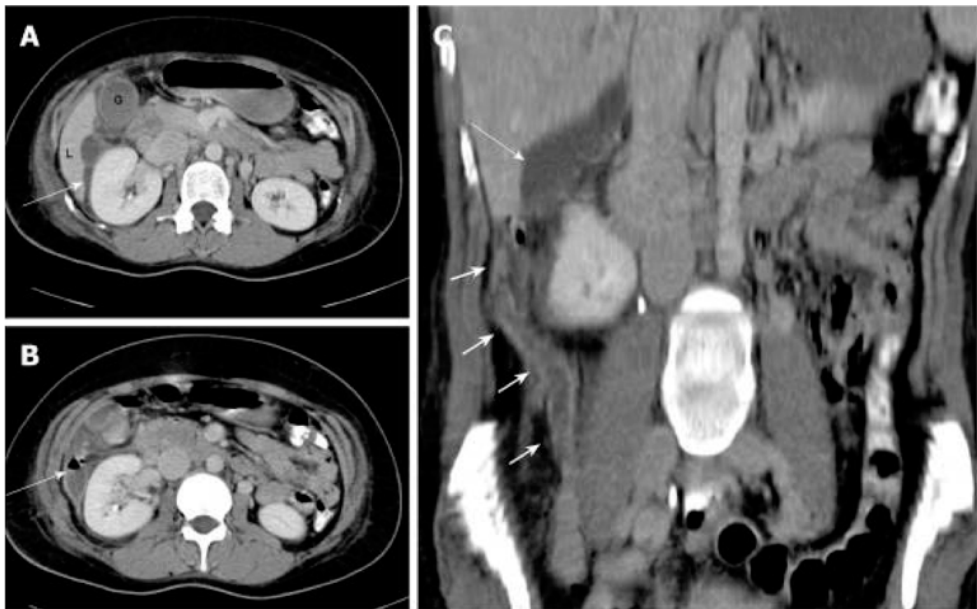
A – contrast-enhanced CT scan showing fluid collection (arrow) in the subhepatic region, extending anteriorly to the gallbladder fossa, B – the air fluid level in the collection adjacent to the right kidney, C – coronal reconstruction showing the long thickened and inflamed appendix (short arrows) reaching the subhepatic region, and the subhepatic collection (arrow) (Assoc. Prof. Viera Lehotska, MD, PhD.)*
